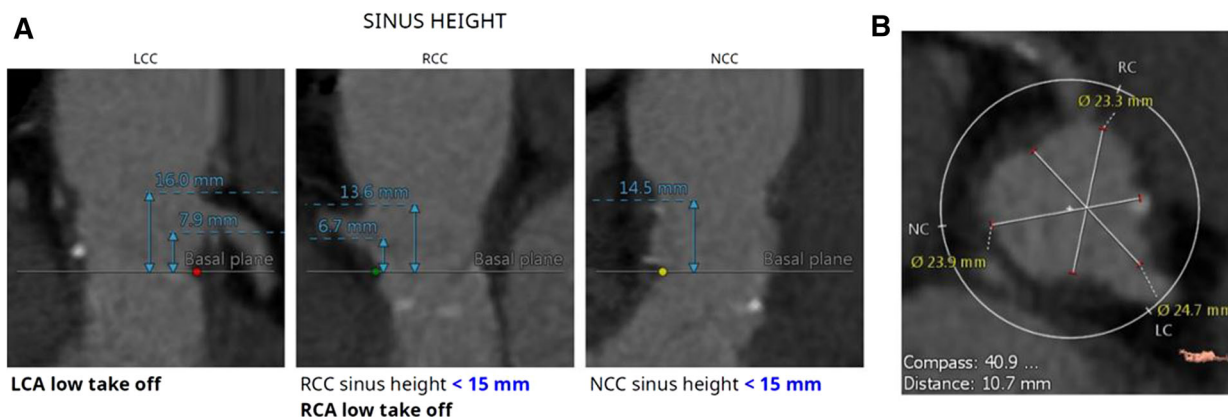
CT angiogram. CTA shows low origin of the right and left coronary arteries with LCA ostium height of 7.9 mm, and RCA ostium height of 6.7 mm (a). The aortic sinuses of Valsalva are also relatively small (b)
